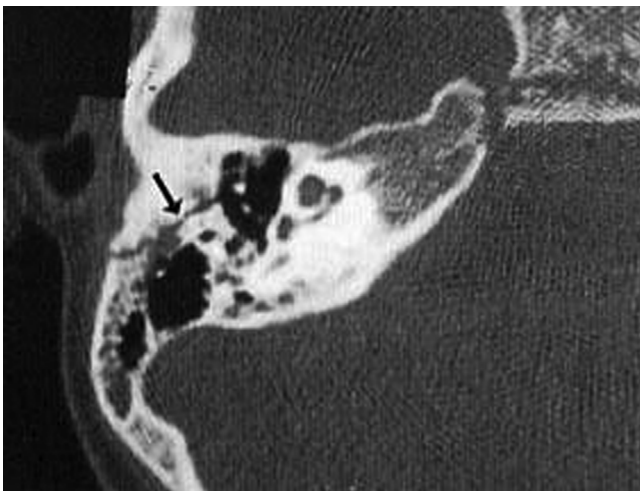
Otic capsule–sparing fracture: representative axial computed tomography image. Arrow points to the fracture line.
